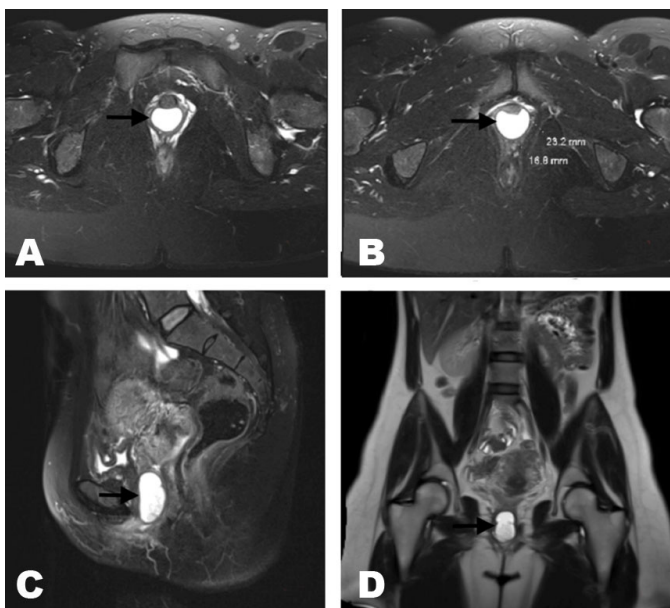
Pelvic MRI: Axial (A, B), sagittal (C), and coronal (D) views of the cystic mass associated with the length of the urethra.
